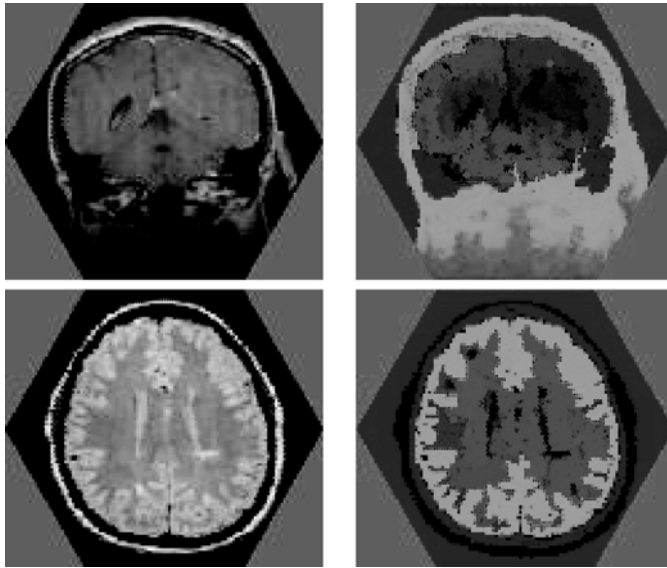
Two images obtained using magnetic resonance imaging (MRI) of heads of patients (left) and the corresponding 3-segmentations (right). (Color slide.)
